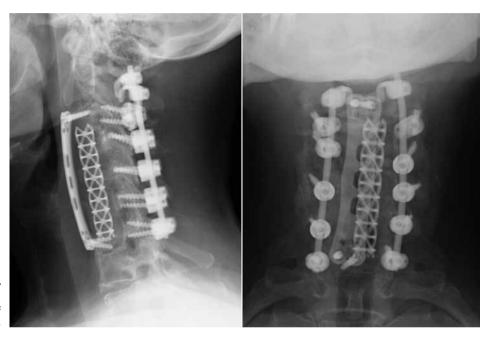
Immediate postoperative X-rays.
